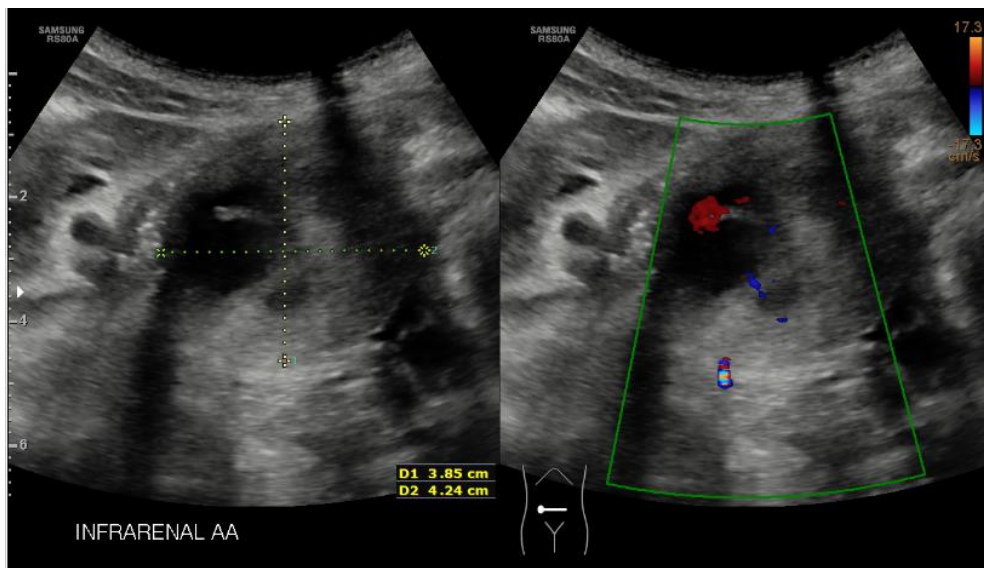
Ultrasound image showing an abdominal aortic thrombus.
